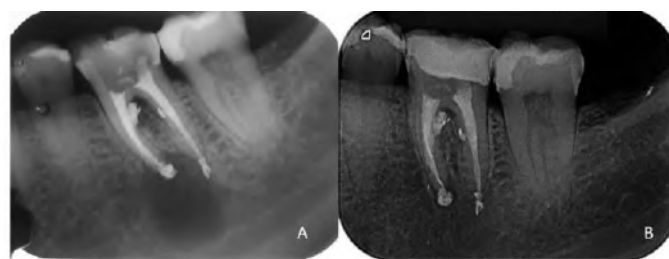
A) Postoperative immediate radiographic control. B) One-year postoperative radiographic control.
